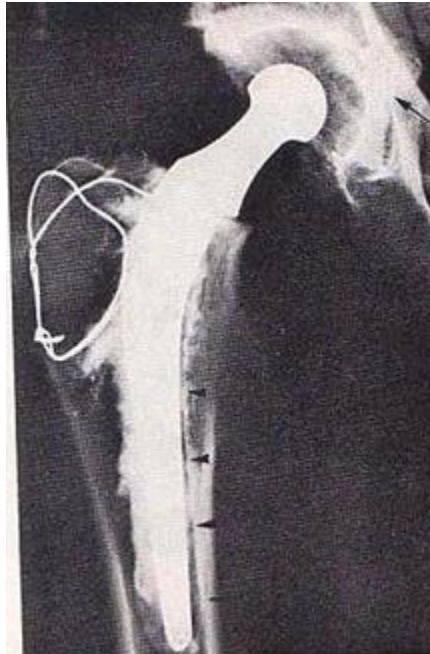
First generation cementing technique (x-ray of total hip replacement)
